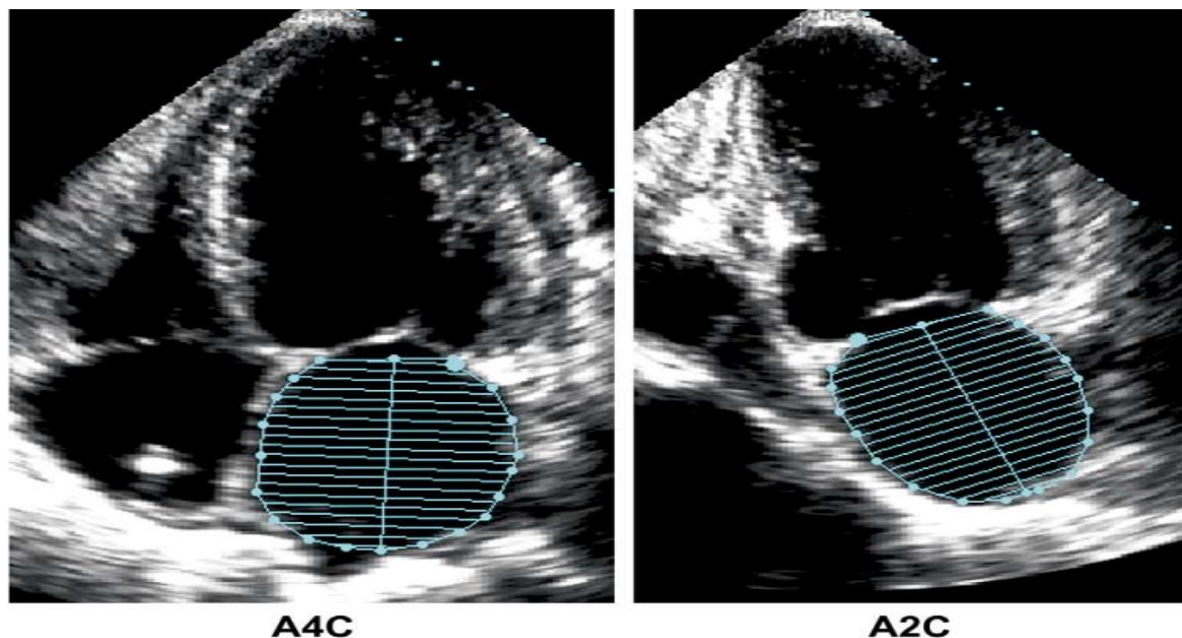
Measuring left atrial volume by apical 4-chamber view (left) and apical 2-chamber view (right) [7]. A biplane (LAV) of [>34 ml/m² for both sexes] is the most reliable predictor of cardiovascular events and a measure of LA size (LA diameter and area). Utilising either the area-length or disc-sum techniques [8].
